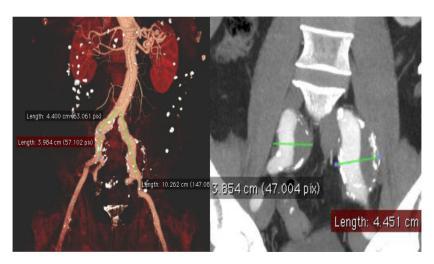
Preoperative computed tomography angiography with reconstructions that demonstrate bilateral common iliac artery aneurysms (CIAAs) and their extent to the bifurcation.
